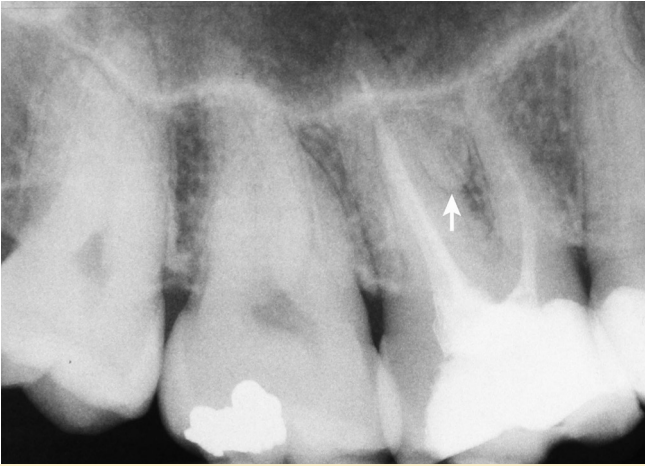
Periapical radiograph of the right permanent maxillary first molar showing the presence of a radiopaque structure between the roots (arrow).
